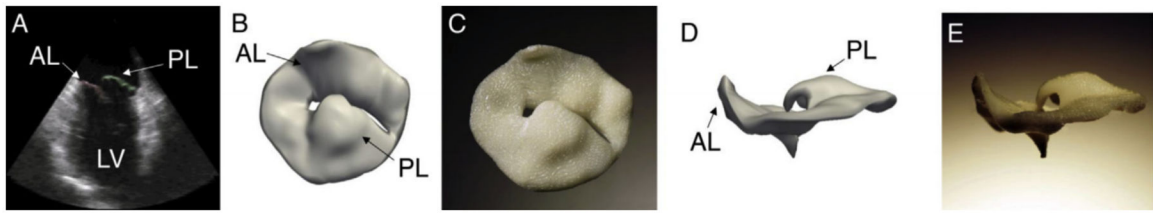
Three-dimensional echocardiography, virtual, and physical models of a patient with severe mitral regurgitation and a flail P2 leaflet segment
